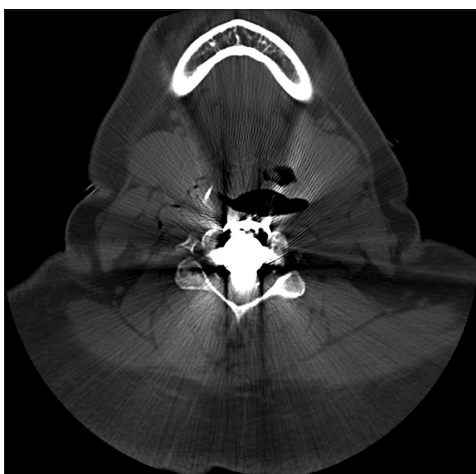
STAT postoperative axial non-contrast CT scan at mid C4 level showing marked metallic artifact from cervical disc arthroplasty device. The presence of the device made it difficult for the radiologist to interpret/identify any pathology within the spinal canal. This further confirmed that a STAT MR was warranted.
